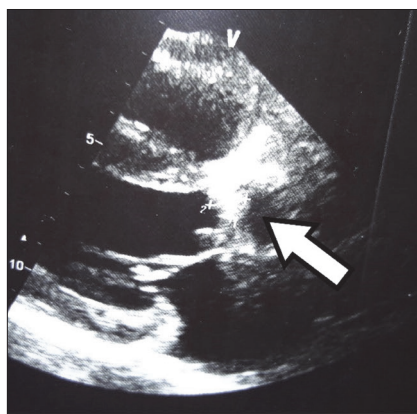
Transthoracic echocardiography (parasternal long axis view): thrombus on the ventricular side of the prosthetic valve in the aortic position (arrow)
